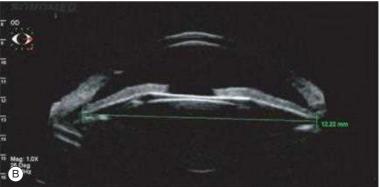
(A) Artemis High-Frequency (50 MHz) 3D-Digital Ultrasound Imaging of the Anterior Segment. Red arrows indicate angle-to-angle distance; yellow arrows indicate sulcus-to-sulcus distance. (B) UBM Vumax II (50 MHz transducer) of a myopic ICL in the posterior chamber. Sulcus-to-sulcus measurement: 12.22 mm. STS diameter measurement is important to determine adequate sizing of the phakic IOL.
